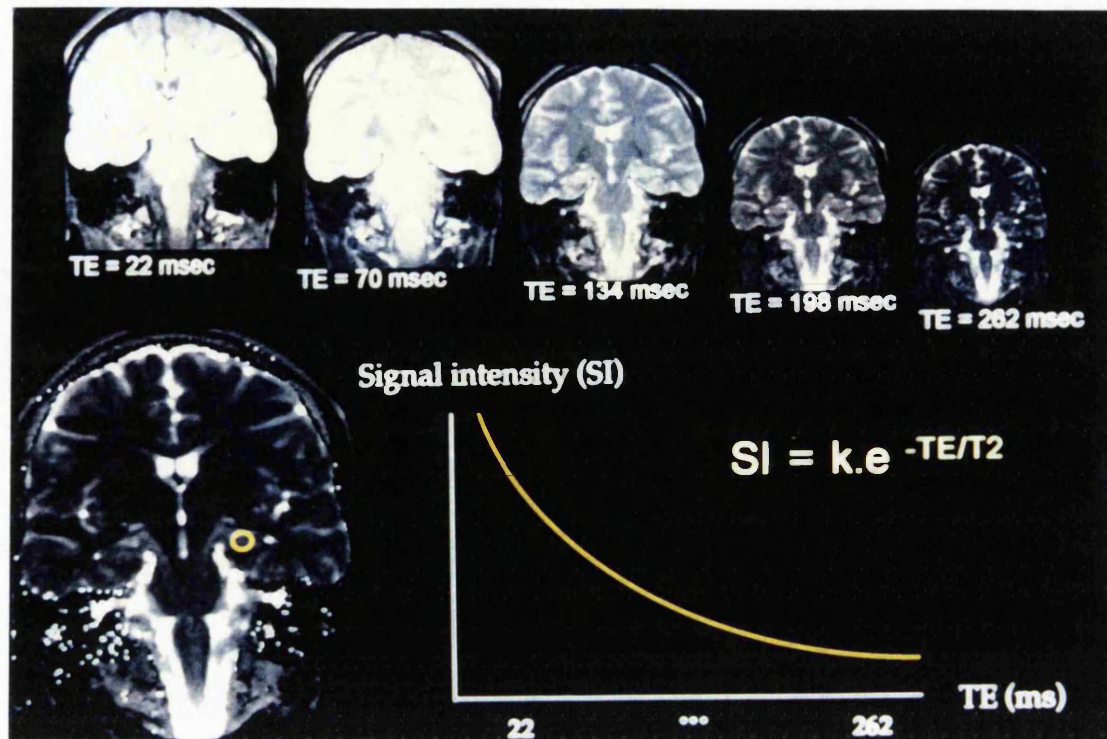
MR images showing the decay of T2-weighted signal and the decay curve.
